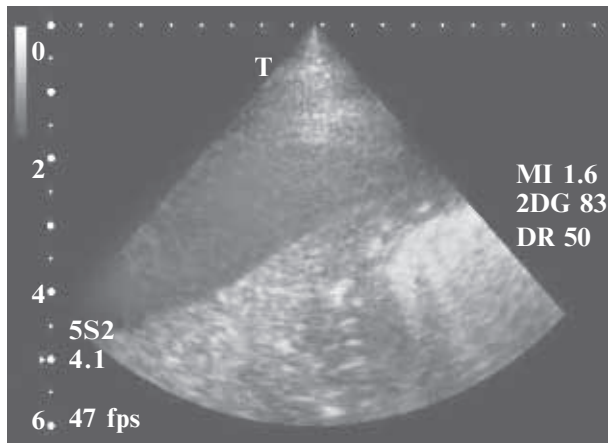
Ultrasound picture of pleural effusion
